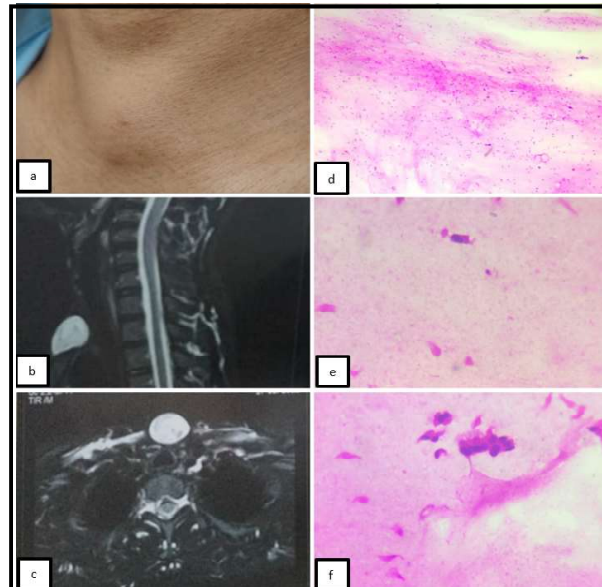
Subcutaneous Bronchogenic Cyst- Clinical Image at the neck b,c Radiological Image MRI Neck shows hypertense lesion without trachea esophageal communication d,e,f Cellular smear shows ciliated columnar epithelium cells admixed with lymphocytes (X4 X10 X40H&E)
